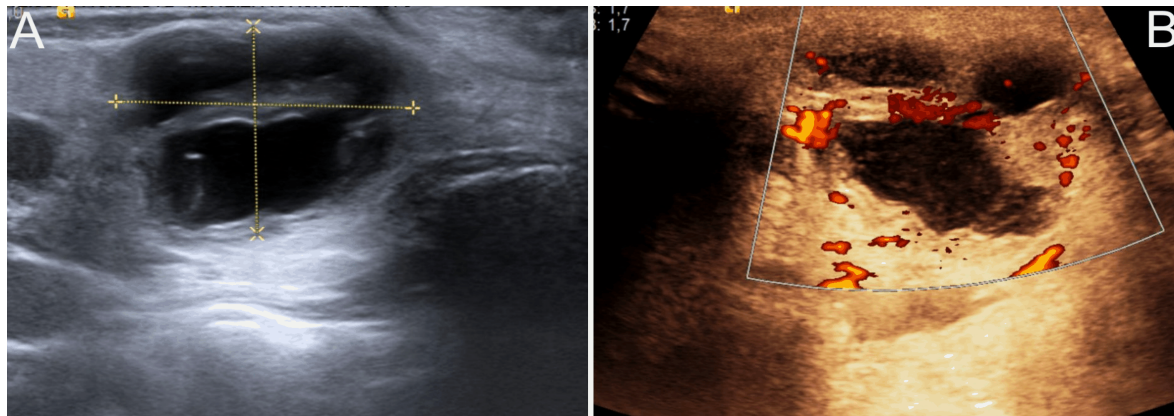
Ultrasonography in B-mode (A) and color Doppler mode (B): a solitary mass in the superficial lobe of the right parotid gland of 27×20 mm dimensions with heterogeneous echotexture, with peripheral intense vascularization, irregular shape, with distal acoustic enhancement divided by a vascularized septum.
